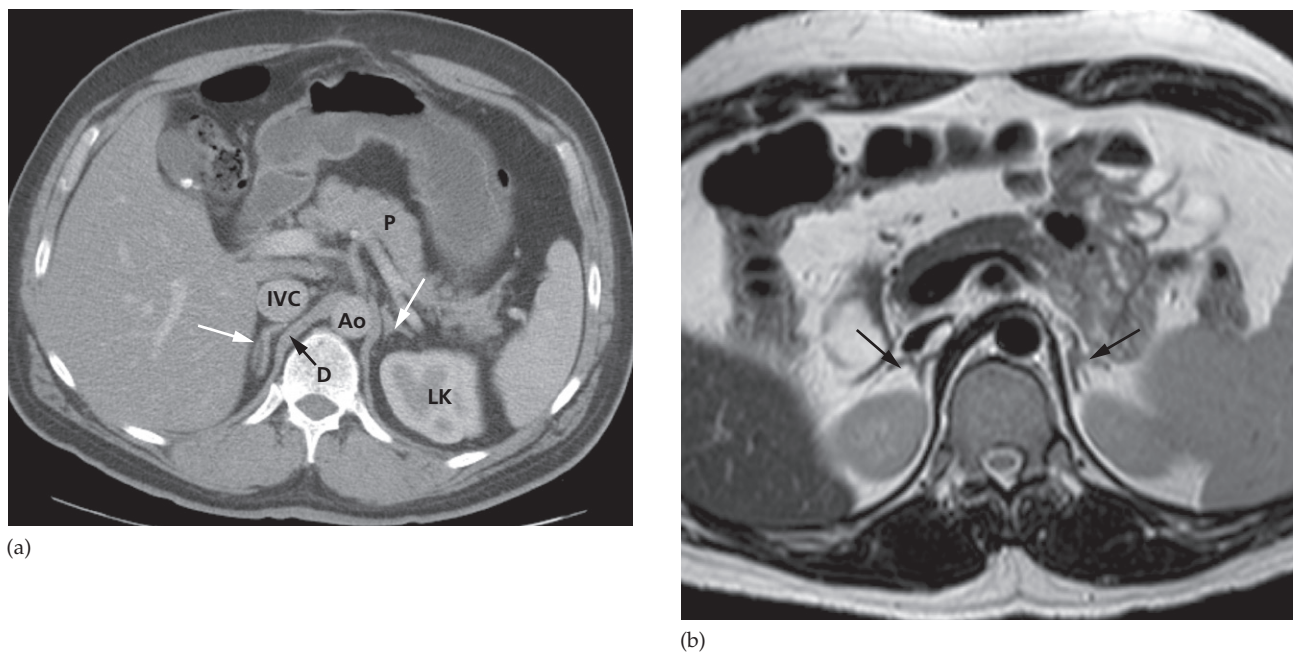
Normal adrenal glands. (a) CT scan. Both adrenal glands (white arrows) are visible in this section. Note the different shape of the two glands. Ao, aorta; D, diaphragmatic crus; IVC, inferior vena cava; LK, left kidney; P, pancreas. (b) MRI scan showing the right and left adrenal glands (arrows), which have an intermediate signal intensity on these T2-weighted images.
